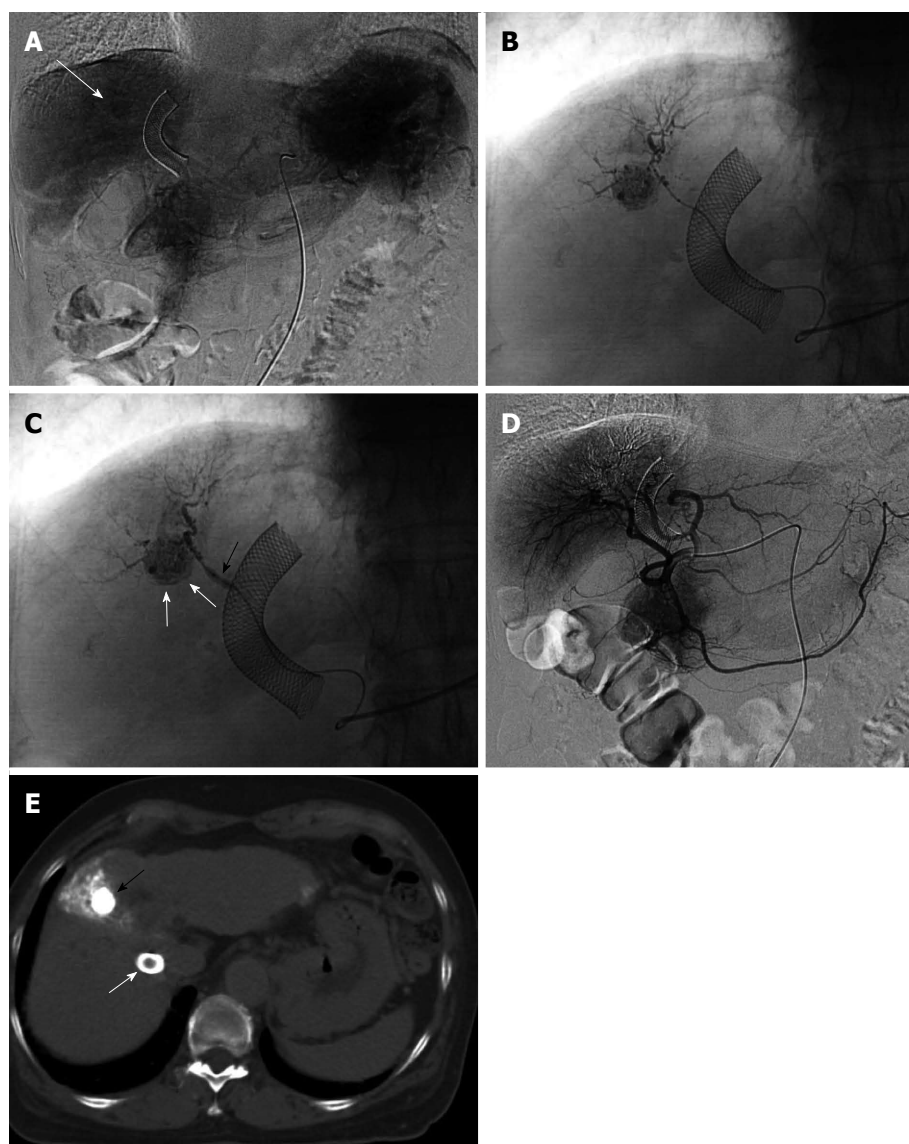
Two-step balloon-occluded transarterial chemoembolization. A 76-year old woman characterized as Child-Pugh class C underwent transjugular intrahepatic portosystemic shunt (TIPS) for massive ascites before several transarterial chemoembolization (TACE) sessions. Celiac arteriography in the venous phase (A) showed a small hepatocellular carcinoma (HCC) (arrow). A microballoon catheter was advanced into the tumor feeding artery. Then, two-step balloon-TACE (B-TACE) was performed. First, tumors were sufficiently embolized by TACE without balloon occlusion of the tumor feeding artery (B); Second, a microballoon catheter was inflated to occlude the feeding artery (C, black arrow), and B-TACE was performed to fully embolize the peritumoral liver parenchyma (C, white arrows). Common hepatic arteriography showed no proximal migration or leakage of embolization materials (D). Following the two-step B-TACE procedure, computed tomography showed dense lipiodol accumulation in the HCC (E, black arrow). There was no evidence of proximal migration or leakage of embolization materials. White arrows indicated a stent for TIPS.
